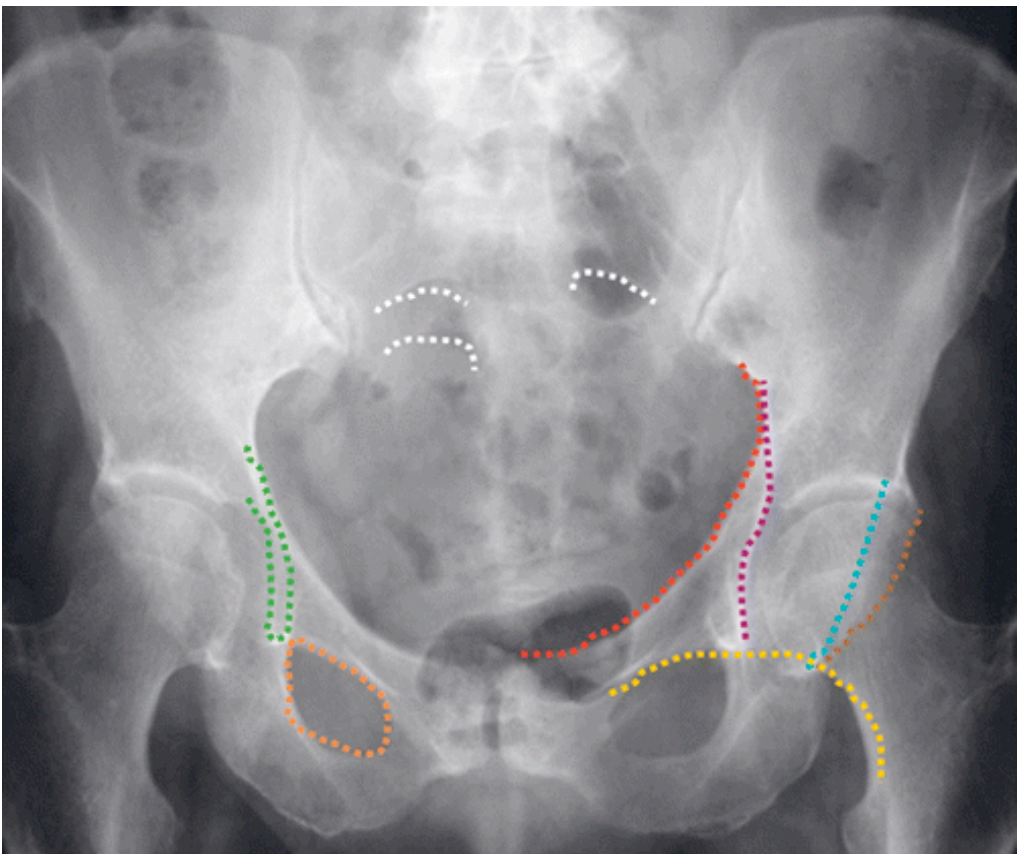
The key contour lines for evaluating the pelvis in an anterior-posterior radiograph: teardrop (green), obturator (orange), iliopectineal (red), ilioischial (purple), Shenton (yellow), anterior rim (blue), posterior rim (brown), and sacral arcs (white). Picture borrowed from the original source (Khurana et al., 2014).
